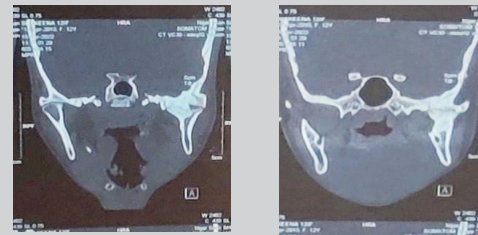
Coronal CT slice of the left temporomandibular joint ankylosis.
